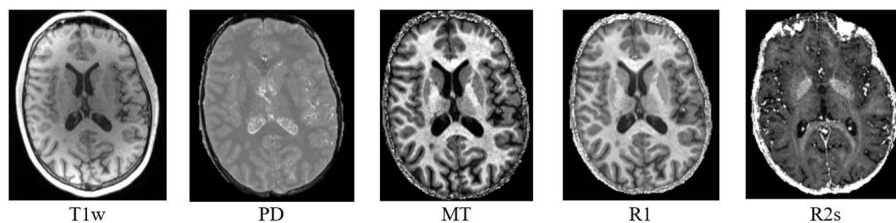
Example of MRI data presented in DS1.
